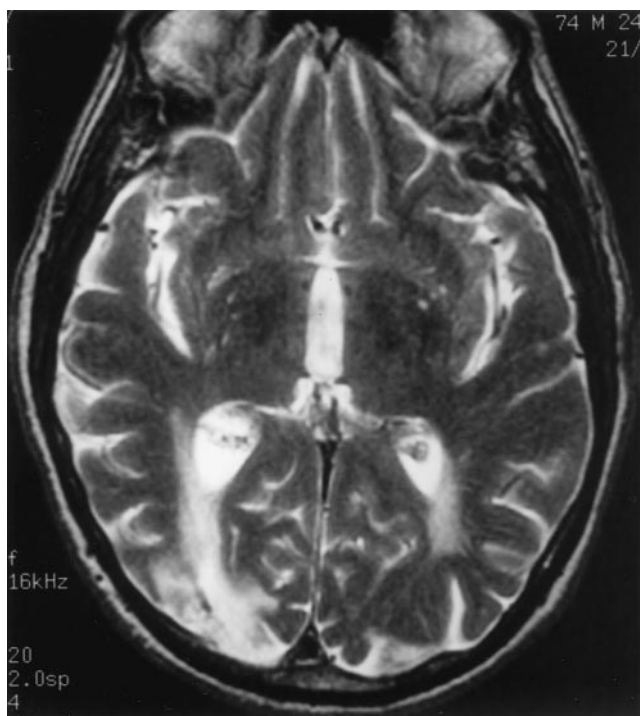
Axial T2-weighted MR image of patient 7 showing an infarct in the right occipital cortex.
